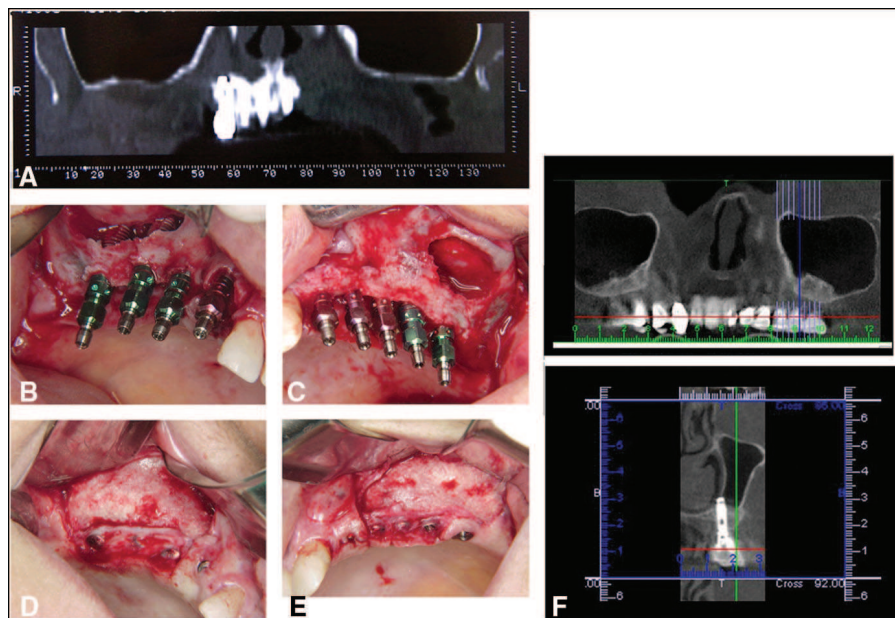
Bilateral sinus in atrophic maxilla. A, CT scan view pre-op – base line subsinus bone; B, implants installed right side; C, implants installed left side; D and E, lateral wall aspect (right and left) after 11 months – complete bone heal; F, CTs view after 5 years.
